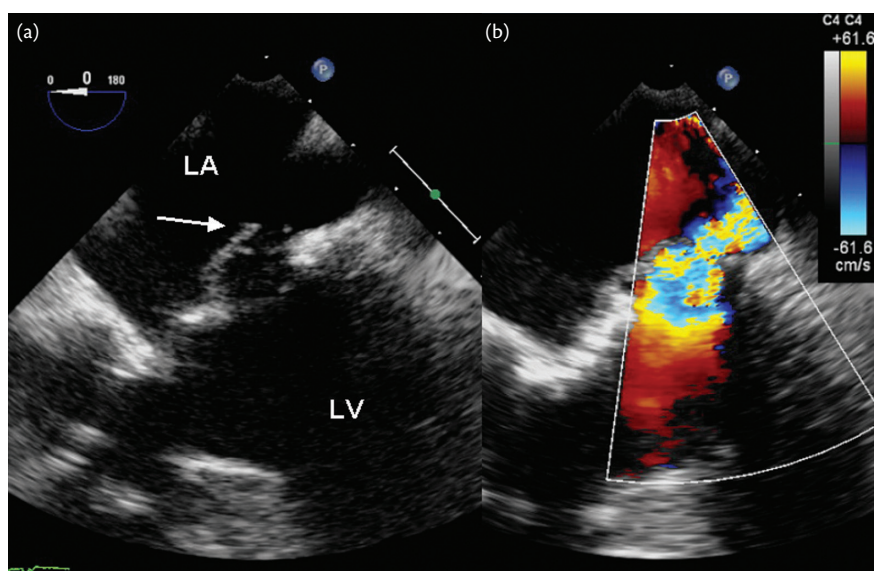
Mitral valve prolapse with a flail of anterior leaflet. Transoesophageal echocardiography. (a) Severe mitral valve prolapse with a flail of posterior leaflet (P2 segment) (arrow). (b) Colour flow imaging showing severe MR with an eccentric jet directed in the opposite direction to the prolapse segment. LA, left atrium; LV, left ventricle. Courtesy of Dr E. Brochet.
